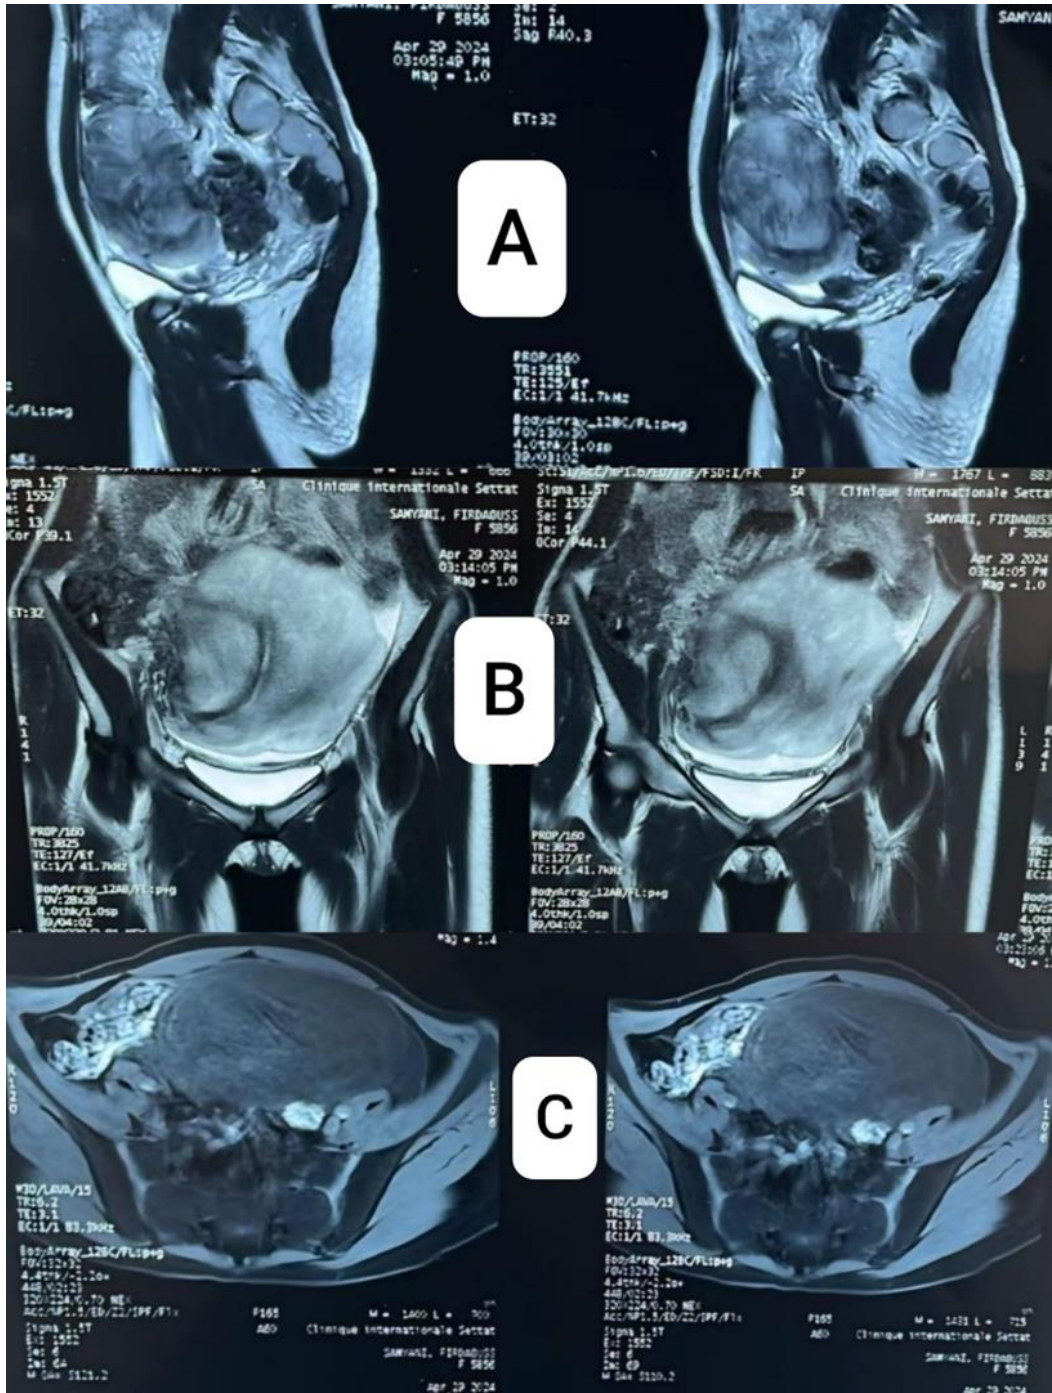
(A) Sagittal MRI image showing a heterogeneous abdominopelvic mass with irregular contours. The tumor is not separable from the caecum. (B) Coronal MRI image showing the tumor invading the small intestine. (C) Axial MRI image showing the caecal tumor with invasion of the small intestine and displacement of ileal loops
